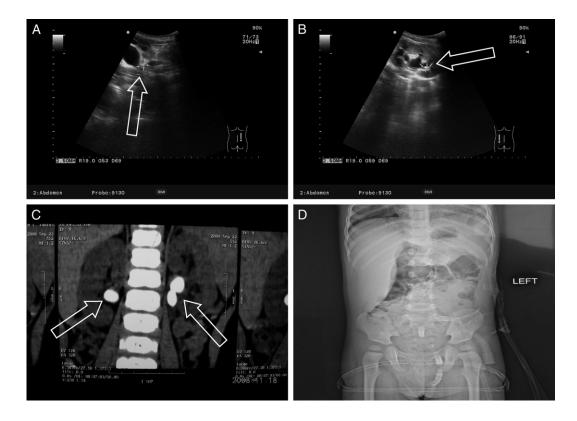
Ultrasound and CT in 16-month-old boy with bilateral calculi. A, ultrasound shows 1 calculus in pelviureteral junction of right kidney. B, ultrasound reveals 2 calculi in left kidney with mild dilatation of pelvis. C, CT demonstrates 1 calculus in pelviureteral junction of right kidney and 2 calculi in left kidney with mild dilatation of pelvis. D, plain x-ray of kidneys, ureters and bladder shows no kidney calculi.
